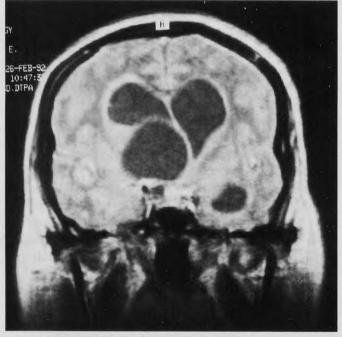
Coronal magnetic resonance imaging with gadolinium reveals a nonenhancing right frontal horn cyst with mass effect.
